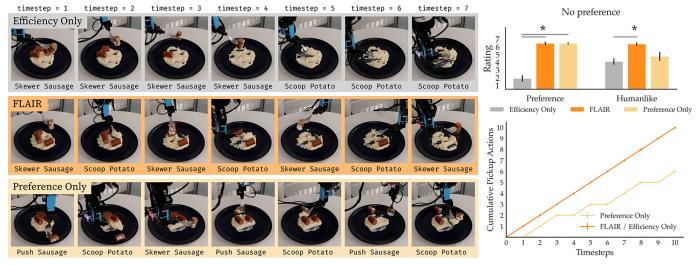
Example run on a plate with mashed potatoes and sausages where the user specified no preference. FLAIR, which balances user preferences (bite variety) and efficiency, is judged by users to better adhere to preferences than Efficiency-Only and outperforms Preference-Only (Commonsense-Only) in plate clearance. Consequently, FLAIR is considered to provide a more human-like feeding experience compared to the baseline methods. Note that * indicates statistical significance (p-value < 0.05), determined via a Mann-Whitney U test.
